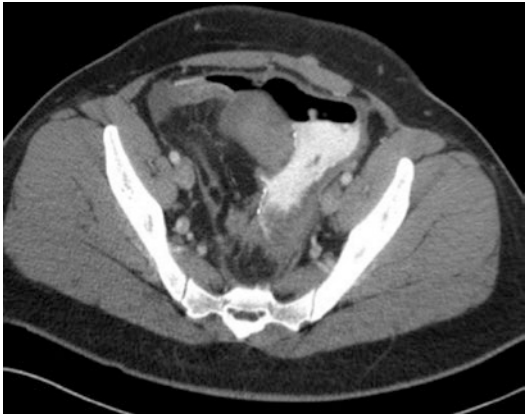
CT showing intra-abdominal desmoid tumor. Note the close proximity to mesenteric vessels
